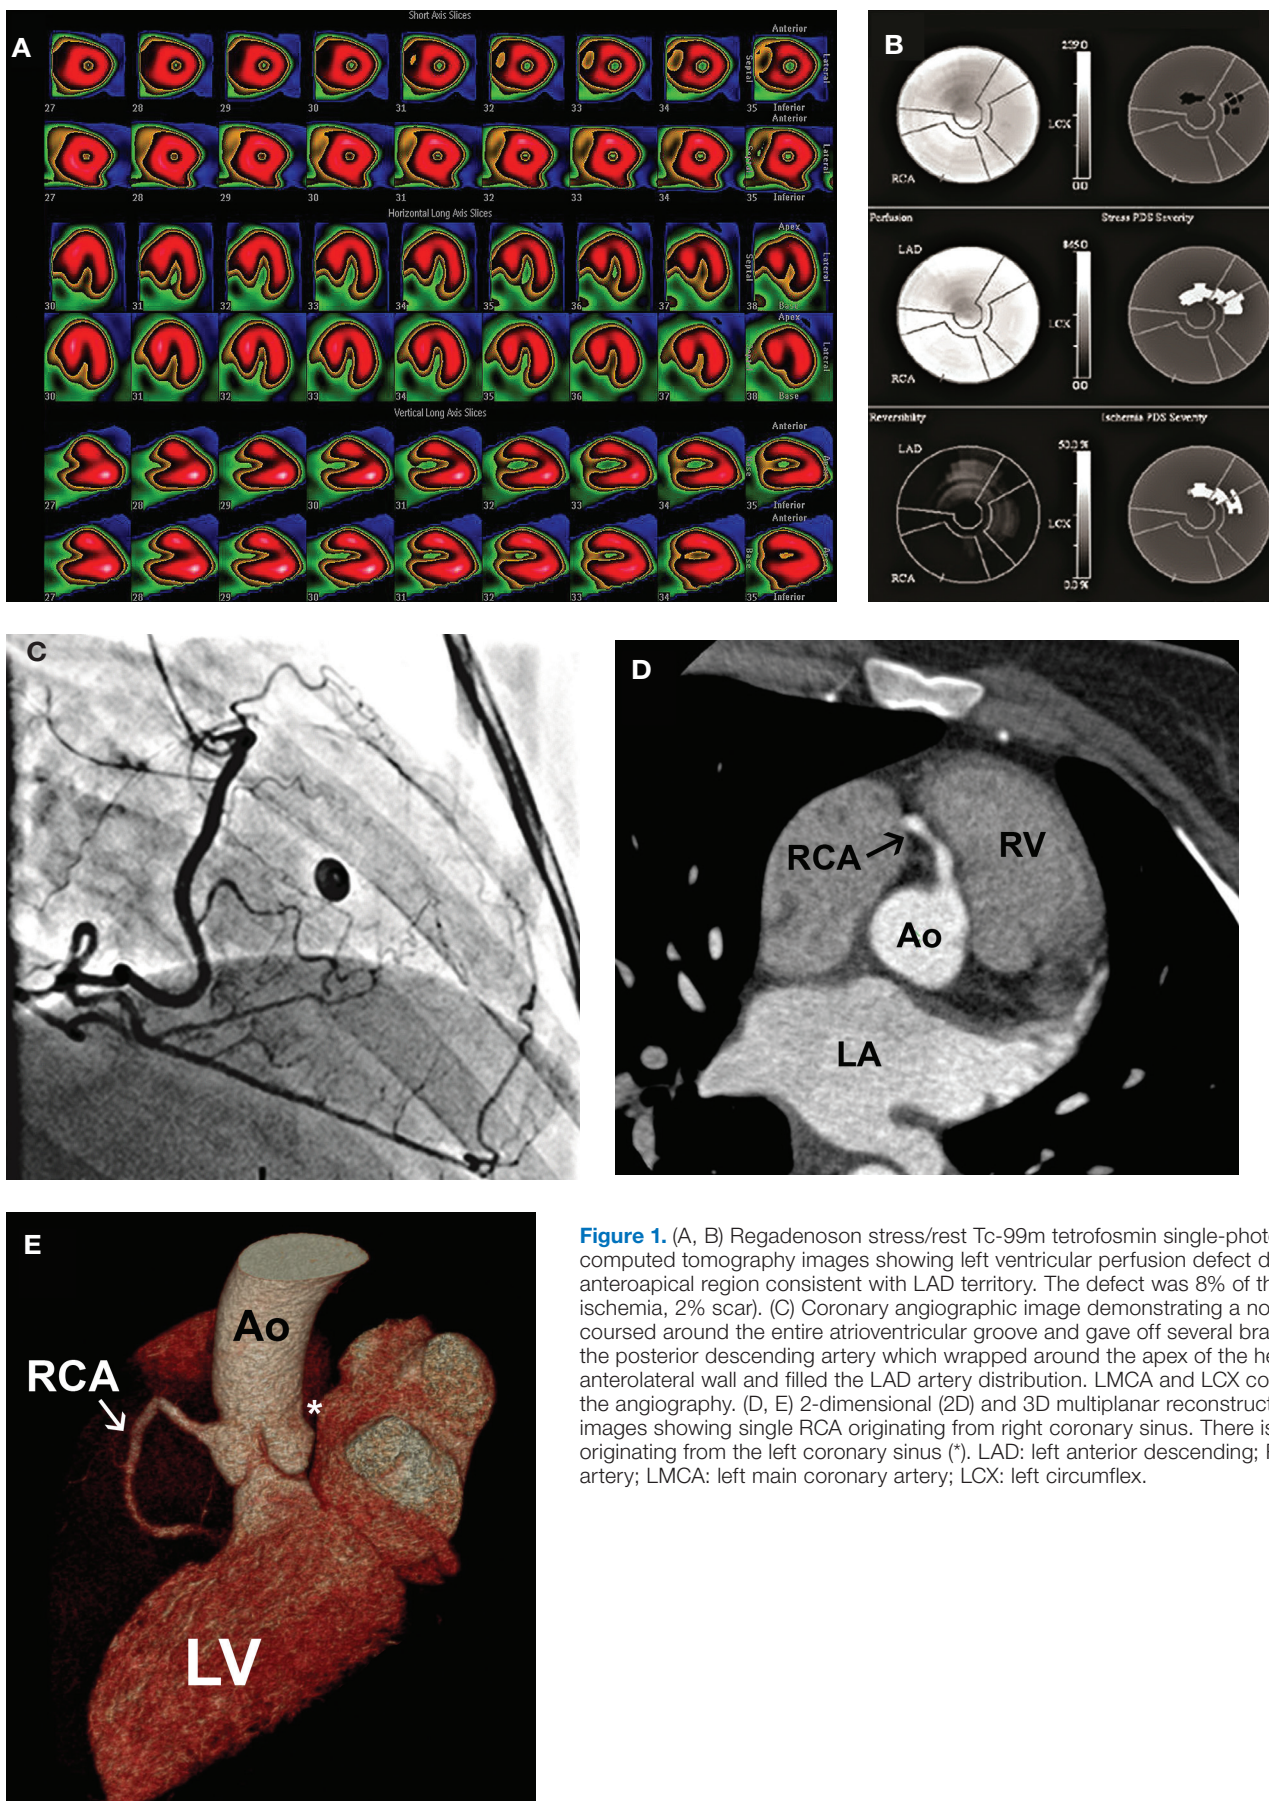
(A, B) Regadenoson stress/rest Tc-99m tetrofosmin single-photon emission computed tomography images showing left ventricular perfusion defect during stress in anteroapical region consistent with LAD territory. The defect was 8% of the total LV area (6% ischemia, 2% scar). (C) Coronary angiographic image demonstrating a nonstenotic RCA that coursed around the entire atrioventricular groove and gave off several branches, including the posterior descending artery which wrapped around the apex of the heart to supply the anterolateral wall and filled the LAD artery distribution. LMCA and LCX could not be seen by the angiography. (D, E) 2-dimensional (2D) and 3D multiplanar reconstruction CT angiographic images showing single RCA originating from right coronary sinus. There is no coronary artery originating from the left coronary sinus (*). LAD: left anterior descending; RCA: right coronary artery; LMCA: left main coronary artery; LCX: left circumflex.
